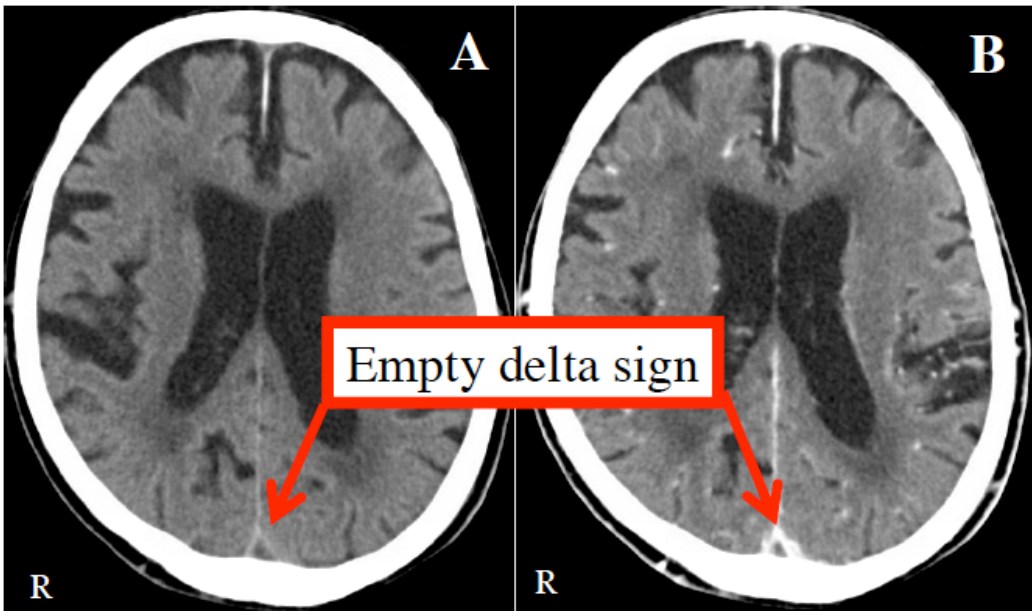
Computed tomography (CT) examination showing an empty delta sign, which is the direct sign of thrombosis in the posterior part of the superior sagittal sinus (A. non-contrast enhanced; B. contrast enhanced).
